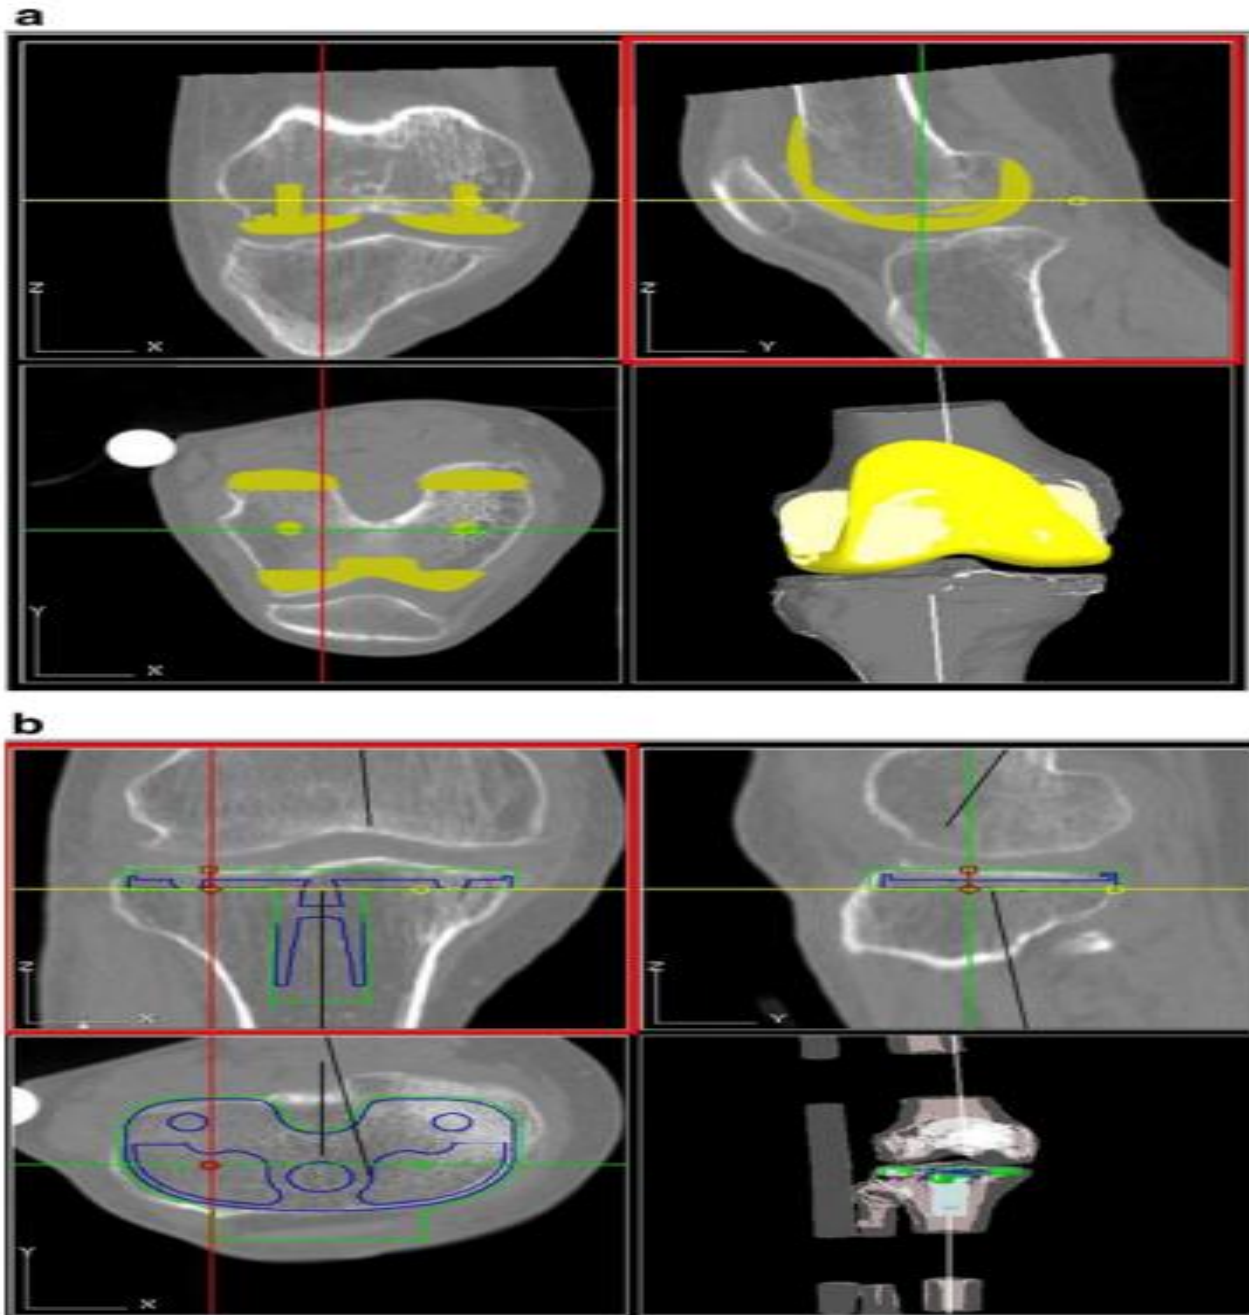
Use of CT-based pre-operative planning for total knee arthroplasty using the ROBODOC® system as used in the study of Song, et al. [116]: a) verification of femoral and b) tibial alignment and size relative to the mechanical axes.
